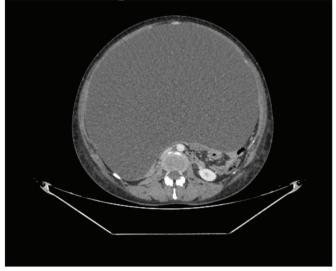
Contrast enhanced computed tomography (CECT) showing large complex solid cystic mass
